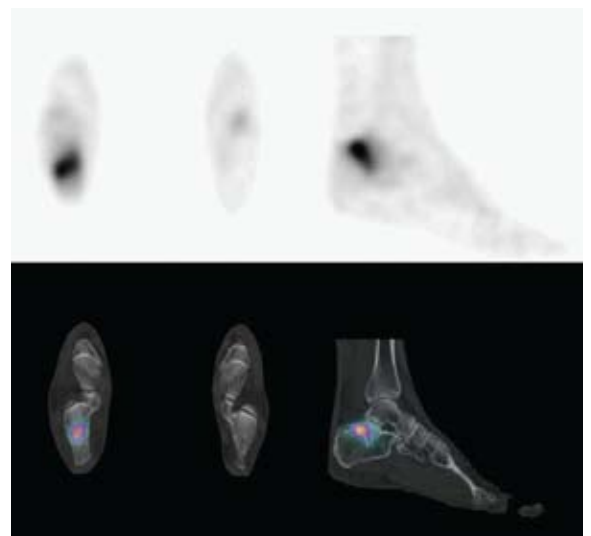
Fusion SPECT/CT with bone scan slice superimposed on CT slice.
